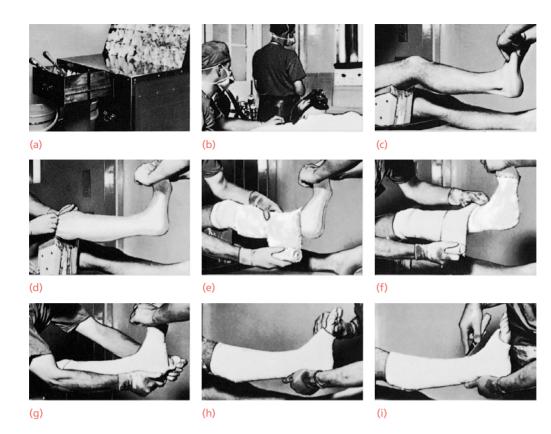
Plaster technique Applying a well-fitting and effective plaster needs experience and attention to detail. (a) A well-equipped plaster trolley is invaluable. (b) Careful study of the X-rays is indispensable. (c) For a below-knee plaster the thigh is best supported on a padded block. (d) Stockinette is threaded smoothly onto the leg. (e) For a padded plaster the wool is rolled on and it must be even. (f) Plaster is next applied smoothly, taking a tuck with each turn, and (g) smoothing each layer firmly onto the one beneath. (h) While still wet the cast is moulded away from the point points. (i) With a recent injury the plaster is then split.
